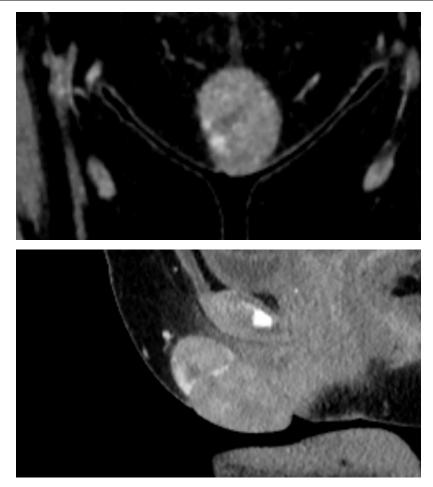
Contrast enhanced axial, coronal and sagittal CT scan images of clitoral mass.
